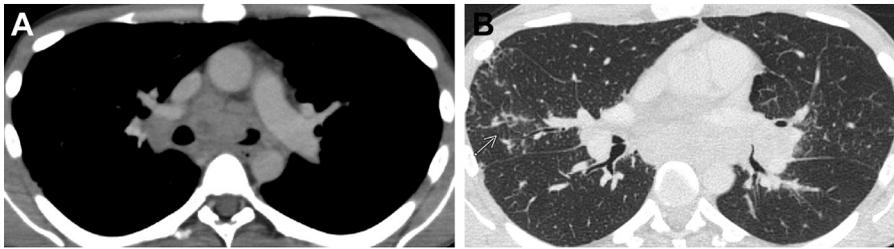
33-year-old man with MonoMAC syndrome (GATA2 mutation). (A) CT shows extensive mediastinal and hilar lymphadenopathy and (B) tree-in-bud nodules in the right middle lobe (arrow).
